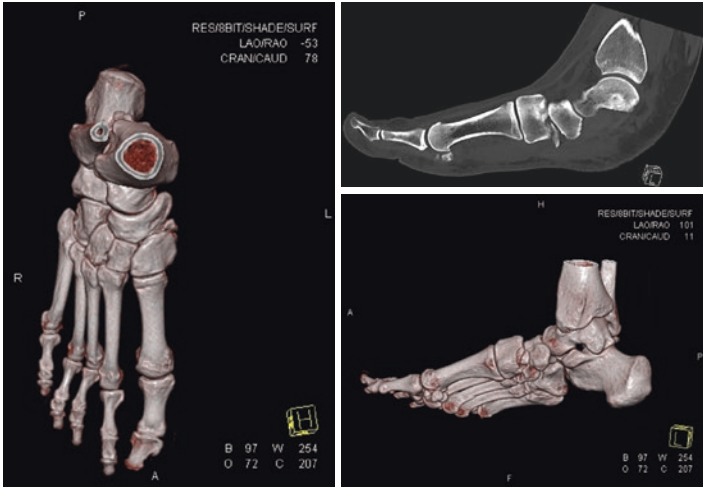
CT scan right foot
